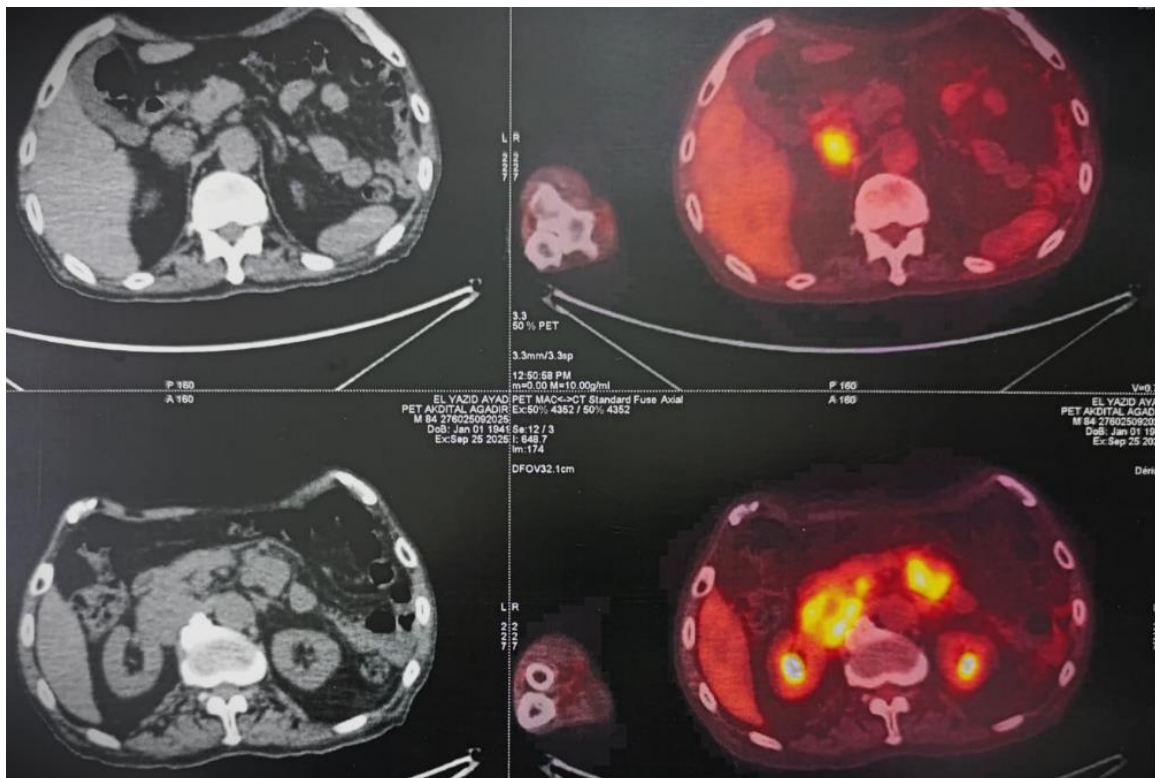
A PET-Scan 18F- FDG was performed, which confirmed: Three hypermetabolic intraperitoneal abdominal tissue lesions associated with interaortocaval lymphadenopathy and a cluster of mediastinal lymphadenopathies.
